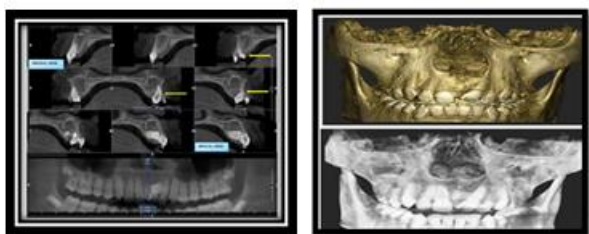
Cbct-Position of supernumerary Teeth
